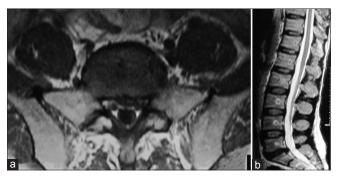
Axial (a) and parasagittal (b) magnetic resonance imaging of lumbosacral spine showing a left paracentral protrusion at L5-S1 space. Severe disc dehydration suggests presence of a degenerative disc disease
